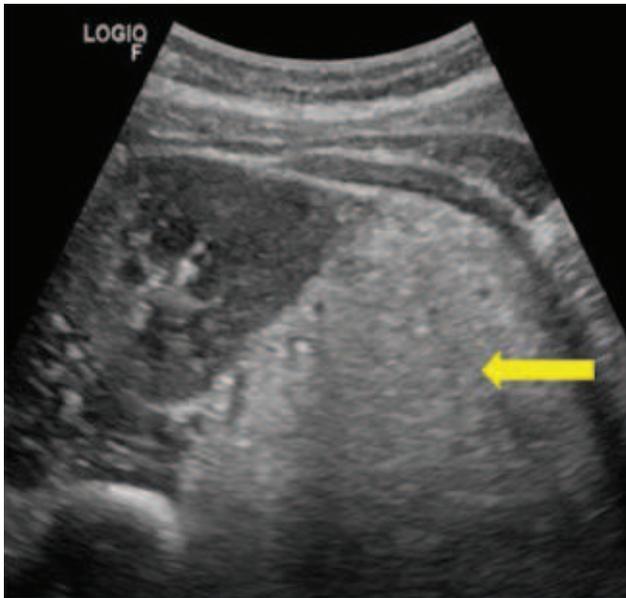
Ultrasound (US) image (axial view) shows an hyperechoic lesion (yellow arrow) in the front surface of the left kidney.
